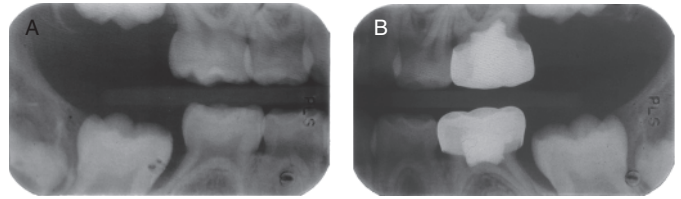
Post-op right and left bitewing radiographs
